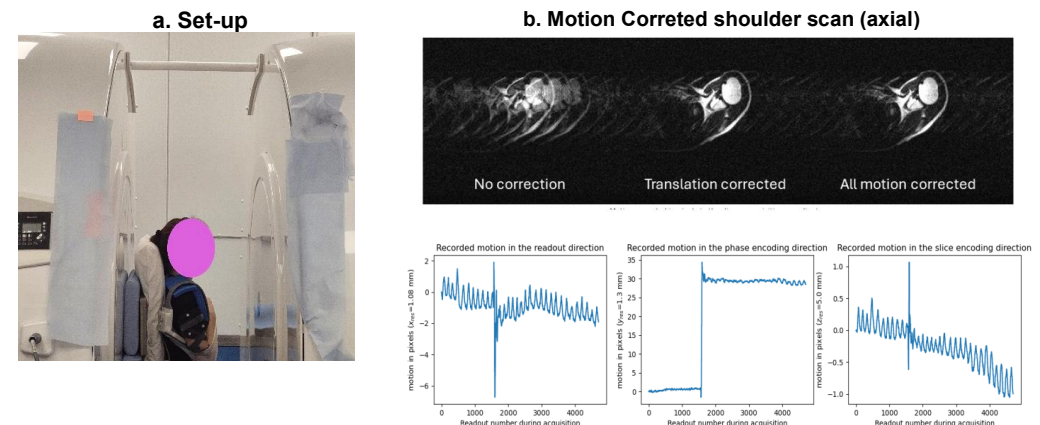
(a) MoCo set-up. The figure shows the patient sandwiched between the open MRI scanner coils to make the shoulder clearly visible to the VDUO optical camera. (b) results for one subject for (approximately) pure translation along z. Residual artefacts on the image are due to an interaction between phase-encoding and system instability. Data show the translations along z axes in the scanner reference frame (on different scales in each case).
